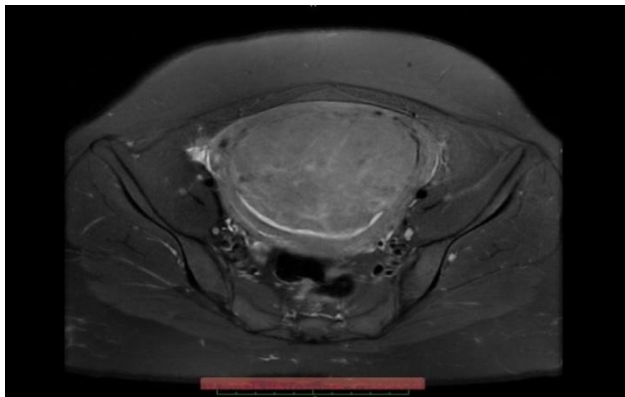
MRI picture of fibroid uterus
